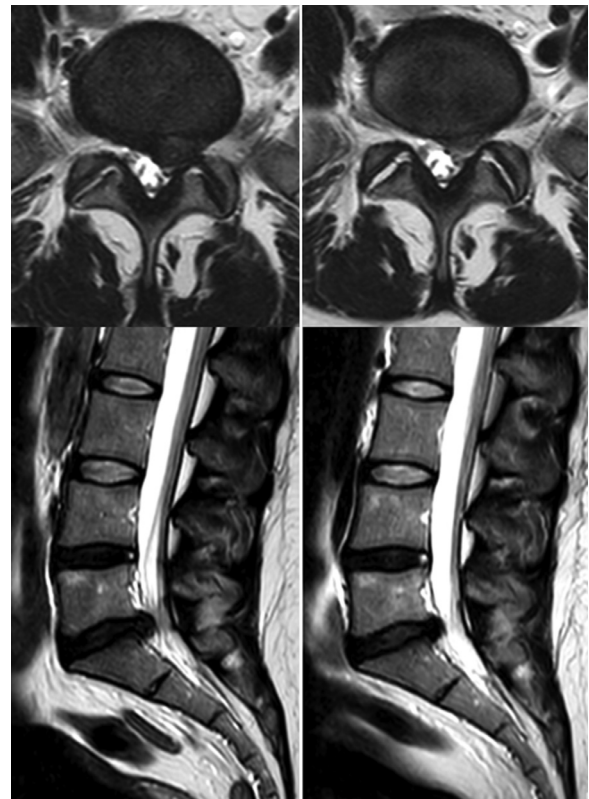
MRI images before and after oxygen ozone treatment. The figures on the left show TW2 images in axial and sagittal sections in a patient with a left median L5-S1 disc protrusion compressing the left nerve root S1. The figures on the right show the control images at 2 months in this same patient after the intradiscal injection of the oxygen-ozone mixture, with a marked decrease in the size of the herniation.
